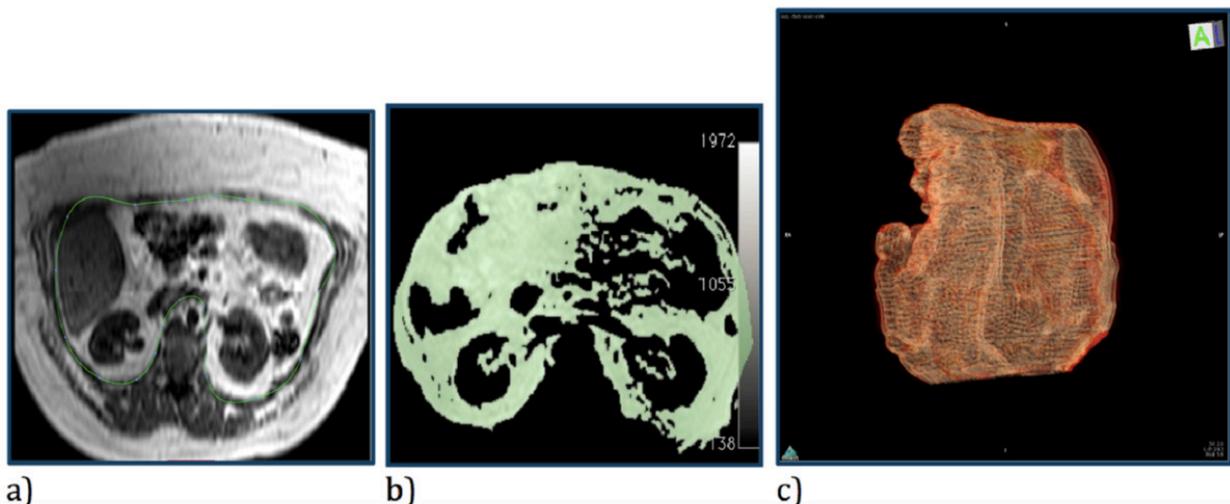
a) GRE T1-weighted abdominal sequence. We traced a ROI to delimit abdominal visceral cavity and fat tissue in it. b) Selecting “threshold” values, we are able to exclude from computation of visceral fat volume bowel loops and main abdominal vessels. c) “Selected” abdominal fat volume rendering at the end of the computation.
